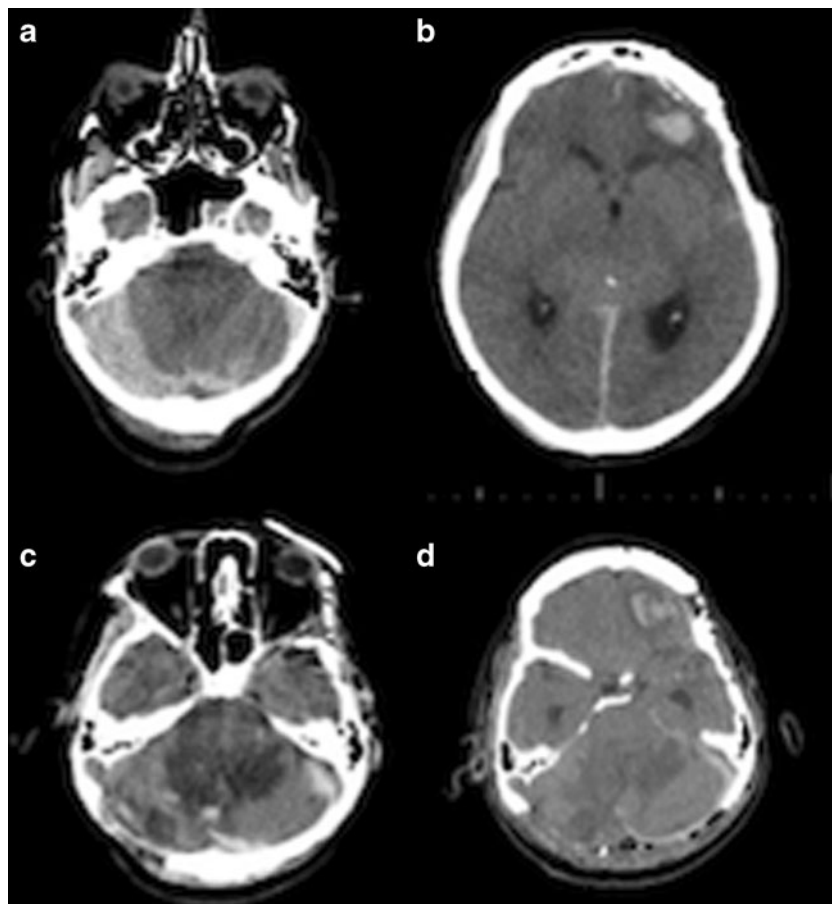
Patient 3: a CT scan showing a right temporal epidural hematoma (EDH) and a laminar posterior fossa SDH (*arrow*) next to the left sigmoid sinus. b Post-operative CT scan 8 h after evacuation of the EDH showed
